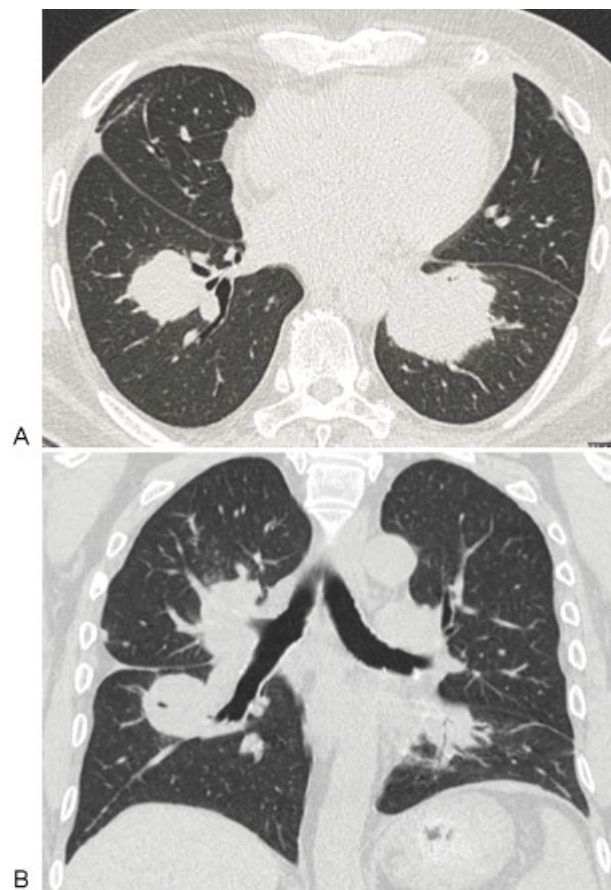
A 60-year-old male patient presenting 6 months postbilateral lung transplant with dyspnea and wheezing. Chest CT (A = axial, B = sagittal sections) showed three mass-like densities in the right suprahilar, right infrahilar, and left infrahilar regions. Biopsy confirmed posttransplant lymphoproliferative disorder, monomorphic diffuse large B-cell type. EBV-EBER in situ hybridization was positive in many large neoplastic lymphocytes. CT, computed tomography; EBER, Epstein-Barr encoding region; EBV, Epstein-Barr virus.
